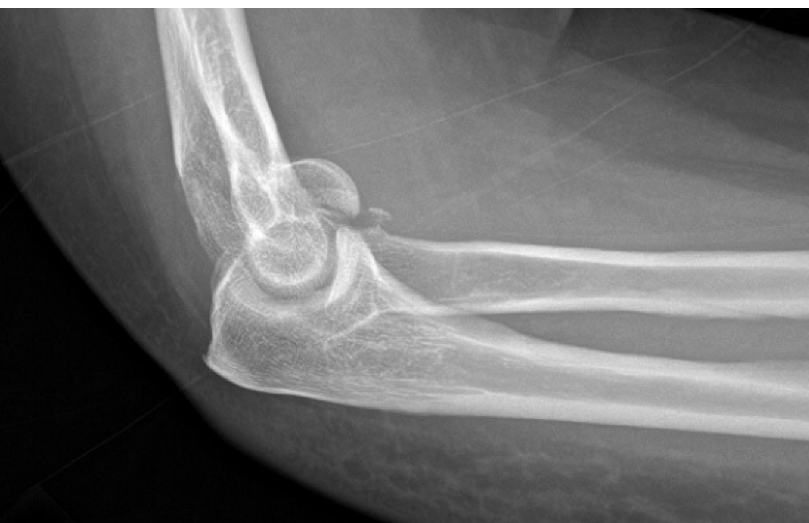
Lateral radiograph demonstrating displaced fractures of the capitellum and lateral condyle. Note the anterior displaced fragment of the capitellum that blocks elbow flexion.
